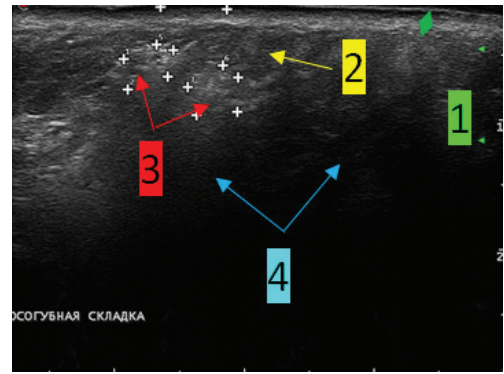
Sonogram of the soft tissues in the projection of the left nasolabial fold (arrow 1 – dermis, arrow 2 – hypodermis). Hyper-echoic structures (arrow 3 – hyperechoic structures) with an acoustic shadow (arrow 4 – acoustic shadow) was visualized into the nasolabial fold soft tissues at the site of the injection of the PMMA filler. Visualization of the underlying structures was not hindered. Echo signs of fibrotic changes into the nasolabial fold soft tissues
